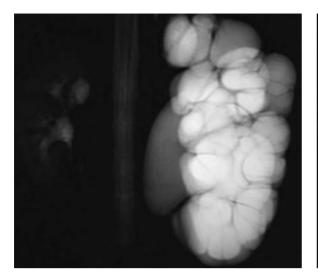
A 12-year-old boy referred for evaluation of hematuria following minor trauma. Ultrasound had revealed left hydronephrosis. T2-weighted coronal image shows severe dilatation of multiple calyces contrasting with a slightly dilated pelvis. Megacalycosis was diagnosed
